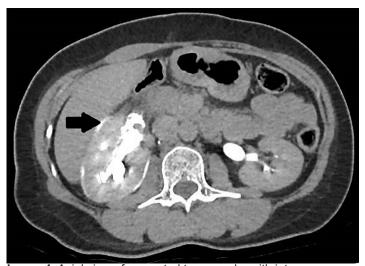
Axial view of computed tomography with intravenous contrast administered showing perinephric leakage (arrow) of contrast showing evidence of ureteric rupture.
